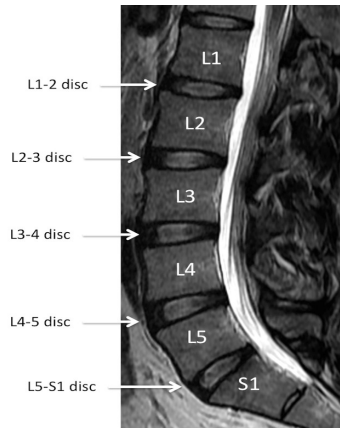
Lumbar Spine MRI Vertebrae Classification.
